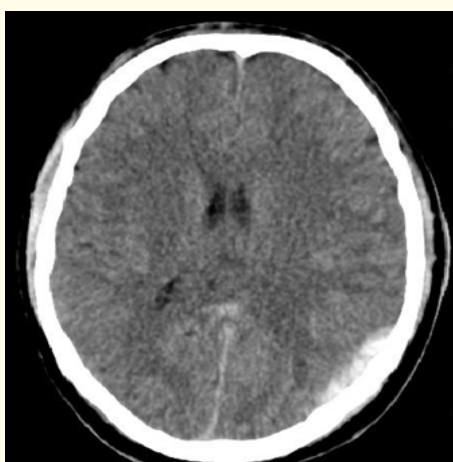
Axial CT section shows cerebral contusions and epidural hematoma.
